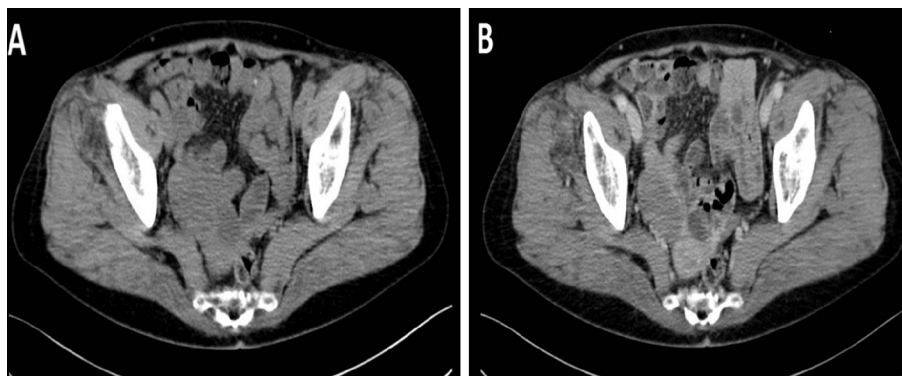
A 67-year-old female with pelvic tuberculosis. Non-enhanced CT scan of the abdomen and pelvis shows an ovoid, well-defined, solid mass arising from the right adnexa measuring  $5.1 \times 2.8$  cm (A). Contrast-enhanced CT scan showing homogeneous enhancement in delayed phase (B).
